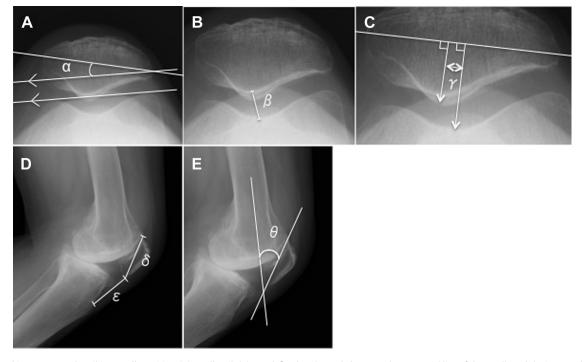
Radiographic parameters describing patella position. (A) Patellar tilt (α) was defined as the angle between the equatorial line of the patella and the intercondylar line in the anteroposterior view. (B) The patellar distance (β) was defined as the distance from the median ridge of the patella to the center of the intercondylar sulcus in the anteroposterior view. (C) Patellar shift (γ) was defined as the distance between the 2 lines passing the cross points of the meridian line and the equatorial line of the patella with the intercondylar line on the anteroposterior view. (D) The Insall-Salvati ratio was the ratio of δ to ε in the lateral view. (E) The patella flexion angle (θ) was the angle between the patellar and femoral axes in the lateral view. A lateral patellar tilt, medial patellar shift, and external rotation angle of the PCA to TEA were considered to be positive values. PCA, posterior condylar axis; TEA, transepicondylar axis.
